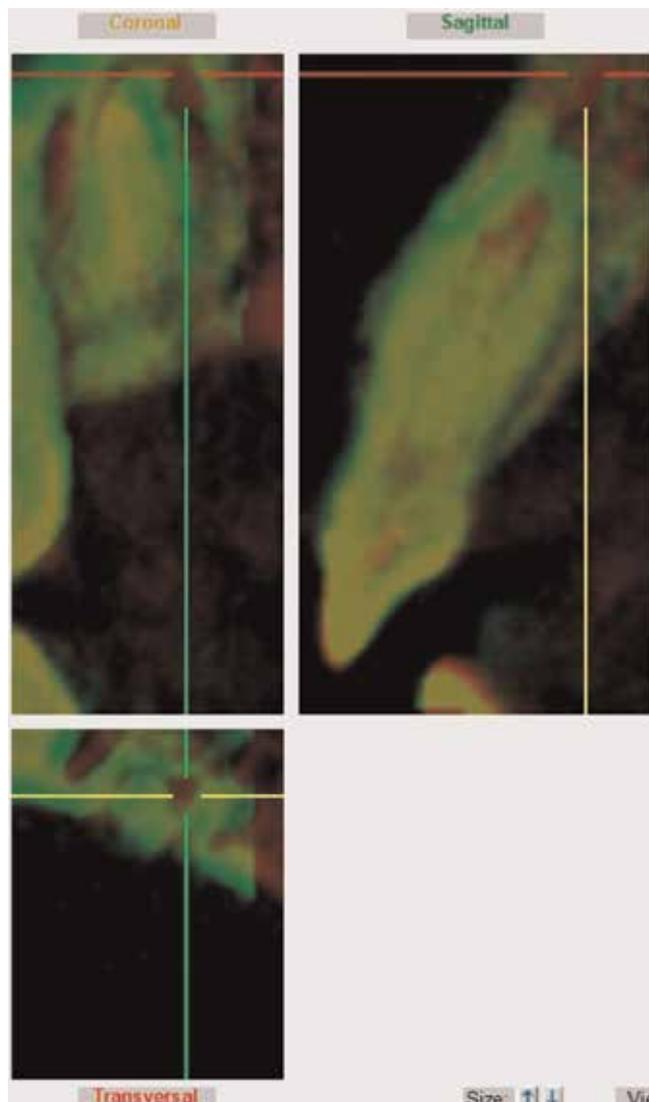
Fusion image of healing of apical granuloma (courtesy of Professor Jozsef Varga). Periapical granuloma was visible at baseline (marked red) that was healed during several months of follow up (marked green) on CBCT scans. The apical granuloma located at the crosshair is visible as red on the fused images in all views.
